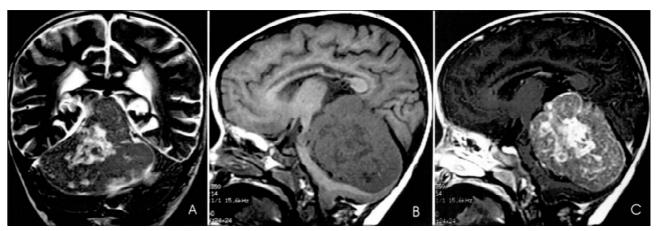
(A) Coronal T2-weighted MRI shows a midline posterior fossa mass in the superior portion of the cerebellum, with heterogeneous high signal. (B) Pre and (C) post-contrast T1-weighted MRI demonstrate the compression on the fourth ventricle and straight sinus, as well as heterogeneous enhancement of the lesion.
